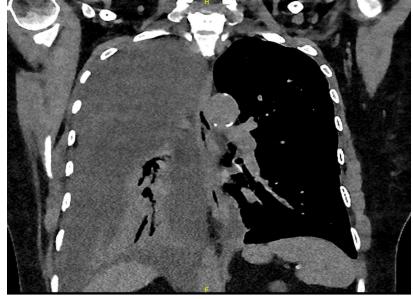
Computed tomography imaging of the chest without contrast showing a right pleural effusion occupying at least one half of the volume of the right hemithorax with complete atelectasis of the right lower lobe with air bronchograms.
